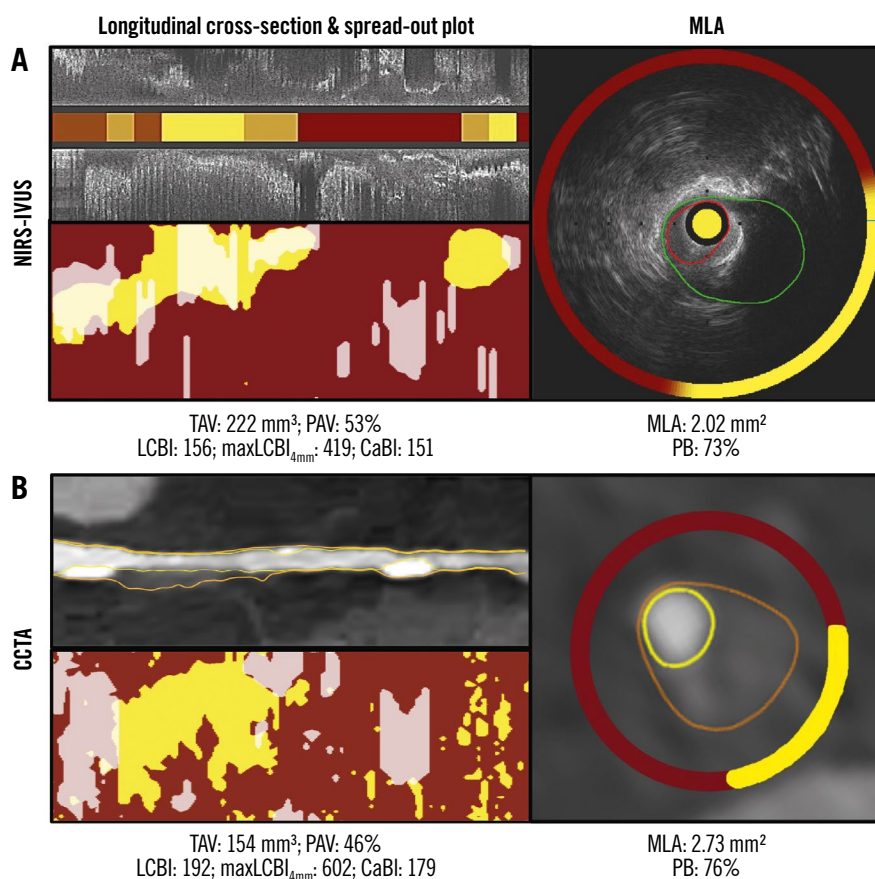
Lumen, vessel wall and spread-out plaque composition analysis of the NIRS-IVUS and CCTA images. A) portrays a longitudinal segment of interest in a left anterior descending artery on NIRS-IVUS, while (B) portrays the corresponding segment of interest on CCTA. The spread-out plots displaying lipid and calcific tissue distribution are also displayed. The TAV, PAV, LCBI, CaBI and $\max LCBI_{4mm}$ estimations of both modalities are shown at the bottom. The cross-sections showing the MLA with the annotated lumen and vessel wall borders and the circumferential distribution of tissue types on NIRS-IVUS and CCTA are portrayed in the images on the right in (A) and (B). CaBI: calcific burden index; CCTA: coronary computed tomography angiography; LCBI: lipid core burden index; $\max LCBI_{4mm}$: maximum LCBI in a 4 mm segment; MLA: minimum lumen area; NIRS-IVUS: near-infrared spectroscopy-intravascular ultrasound; PAV: percentage atheroma volume; PB: plaque burden; TAV: total atheroma volume
